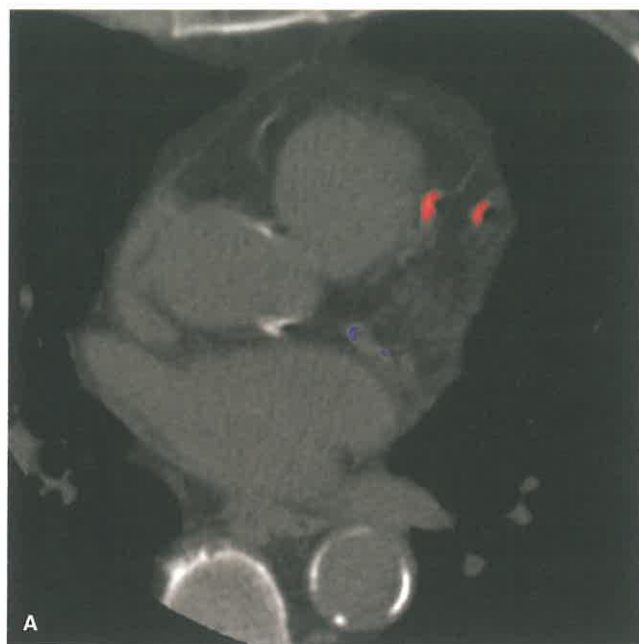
Calcium Scoring for Prediction of Future Cardiac Events. A 73-year-old asymptomatic man with a history of hypertension, smoking, and hyperlipidemia undergoes a calcium score CT. A: Axial image from a calcium score CT shows areas of atherosclerotic disease in the LAD distribution and LCx distribution marked as red and blue, respectively. B: The patient's total calcium score via the Agatston method was 1,121 which places the patient in the 83rd percentile for patients of the same age, gender, and ethnicity who are free of clinical cardiovascular disease and diabetes.
